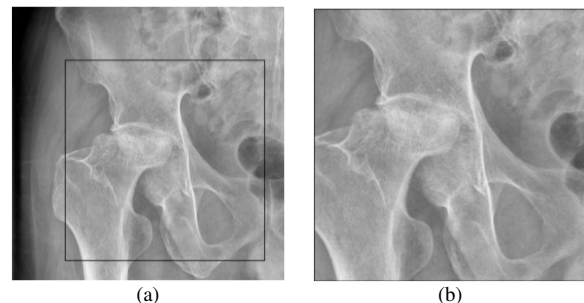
Hip X-ray: (a) Original image, (b) ROI image.
